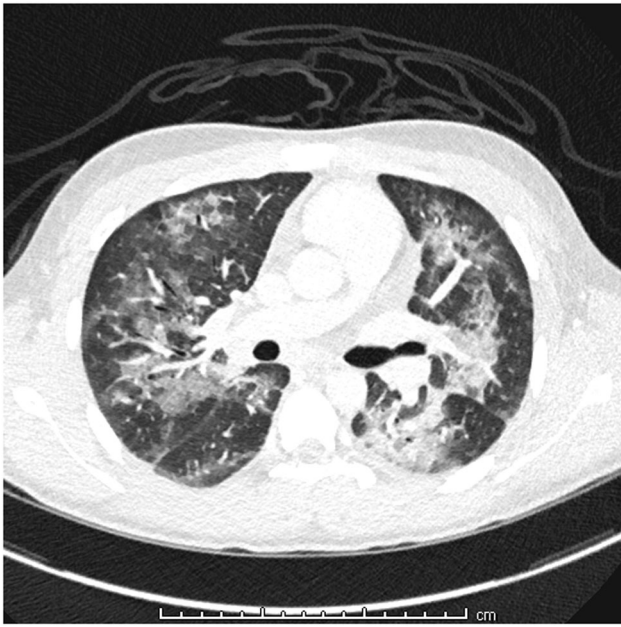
Case 1, chest CT: bilateral ground-glass opacification in "bat wing" configuration. CT, computed tomography
